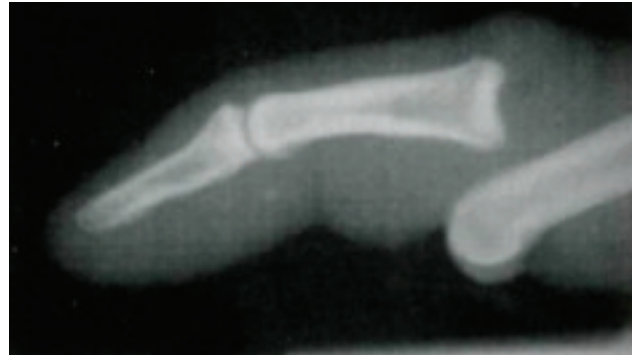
Radiograph of dorsal PIP joint dislocation.
